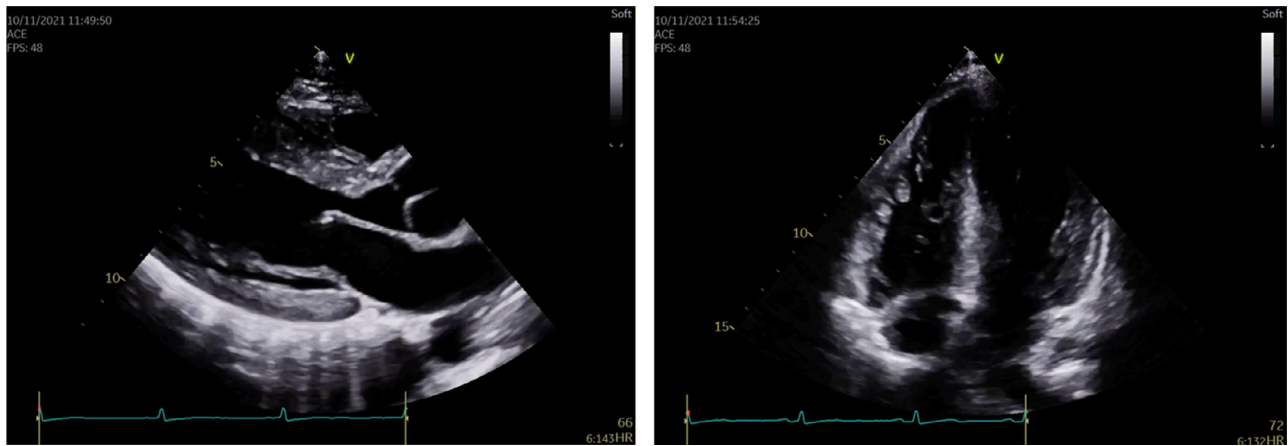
Transthoracic echocardiography revealing LV hypertrophy (septal thickness 17 mm) and normal systolic function. Systolic anterior motion of the mitral valve and right ventricle hypertrophy (free wall thickness of 11 mm).
